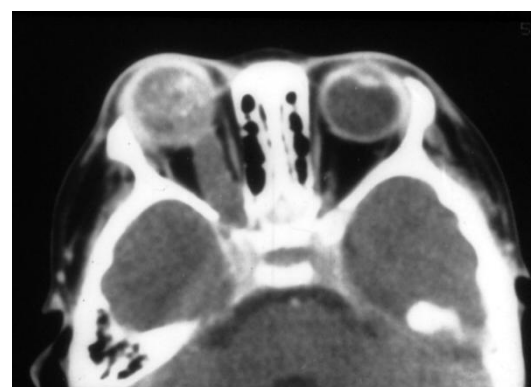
Axial CT Image of Right Eye Retinoblastoma with Optic Nerve Extension.Soft tissue mass with punctate calcification within the right eye, thickening of the optic nerve, and tumor invasion of the middle cranial fossa.
